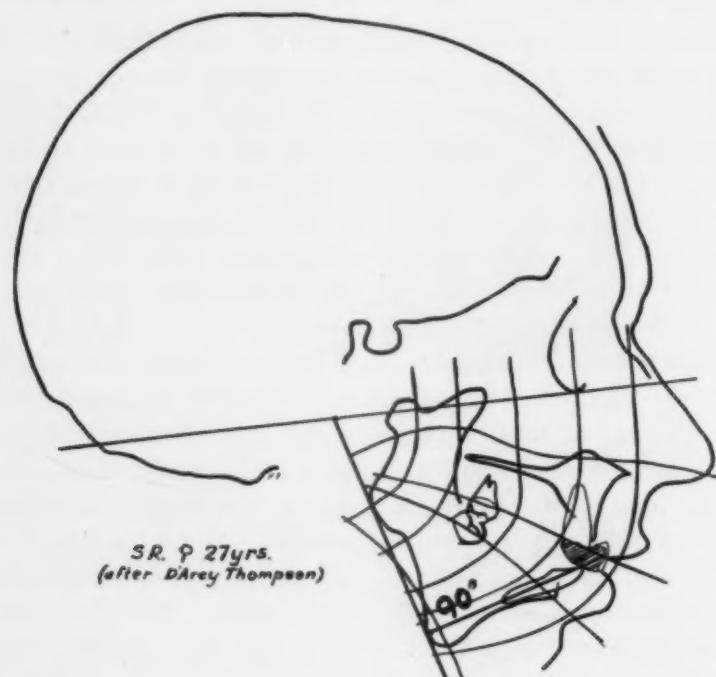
Right angled incisor-mandibular plane angle drawn upon tracing of lateral x-ray headplate. (Original tracing of headplate taken from Wylie, W. L.: AM. J. ORTHODONTICS AND ORAL SURG. 32: 57. 1946.)
